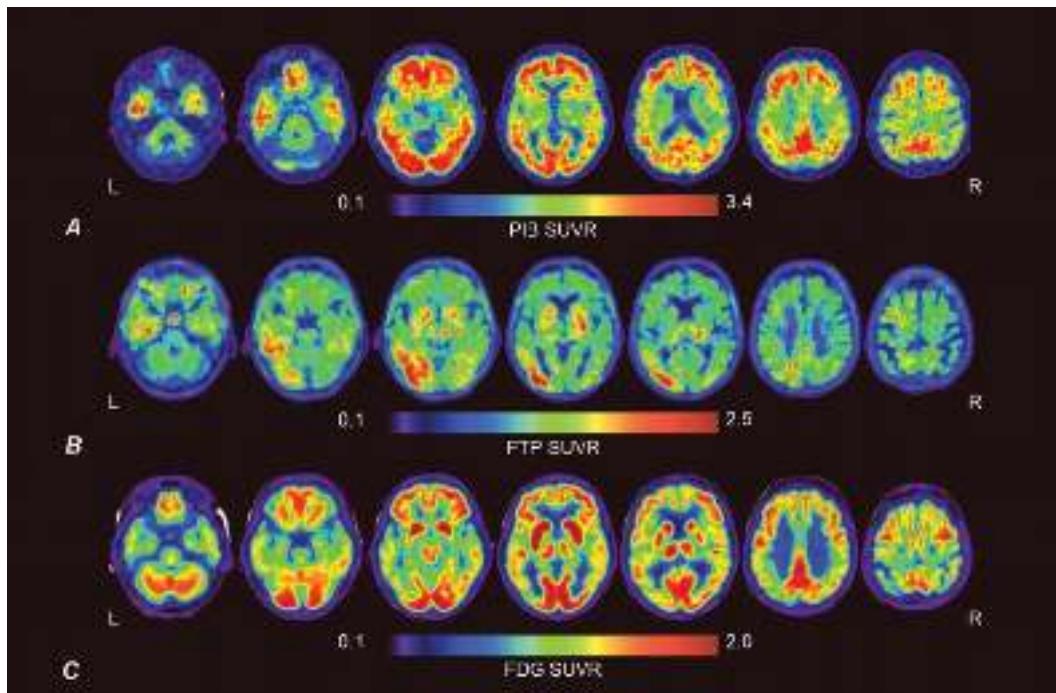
Molecular imaging of Alzheimer's disease pathophysiology in an 81-year-old with mild Alzheimer's disease. A. A β positron emission tomography (PET) with [^{11}C]PiB reveals extensive radiotracer retention in neocortex, consistent with the known distribution of amyloid plaques. B. Tau PET with [^{18}F]FTP shows asymmetric uptake predominantly in left temporal cortex, consistent with intermediate-stage NFTs. Tracer uptake in midbrain and basal ganglia represents "off-target" (non-tau related) tracer retention. C. FDG-PET reveals reduced tracer uptake in left greater than right temporal and parietal cortex, indicative of decreased synaptic activity. The pattern of hypometabolism corresponds more closely to the pattern of tau than amyloid deposition. A–C. Axial brain slices are shown in neurologic orientation. L, left; R, right; SUVR, standardized uptake value ratio, a quantitative measure of PET radiotracer retention.
